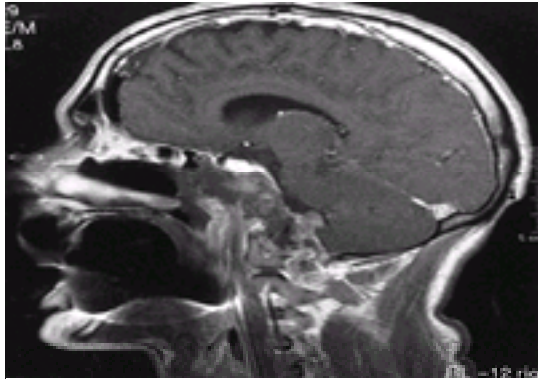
Chordoma. Parasagittal T₁-weighted gadolinium-enhanced MRI showing a hypointense lesion obliterating the normal contours of the clivus and extending into the posterior fossa and abutting the pons and cerebellum. A portion of the lesion extends into the posterior nasal cavity. The ill-defined nature of the boundaries of this lesion are appreciated on this image.
